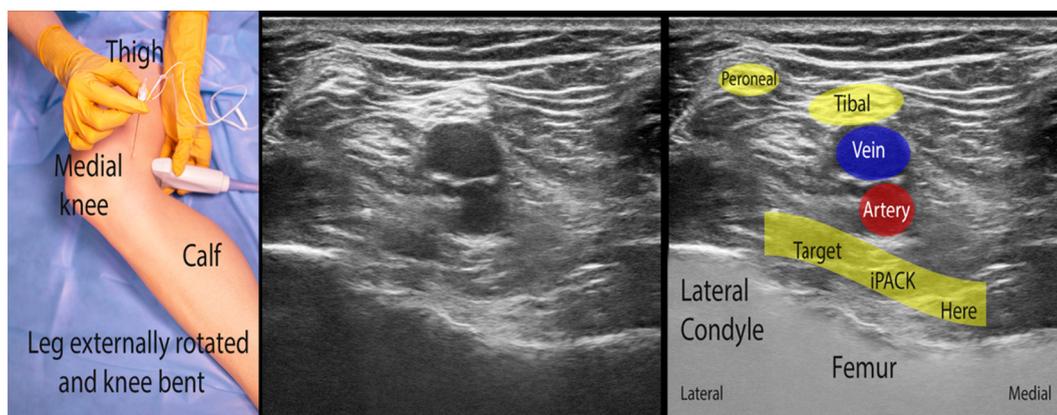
Placement of ultrasound guided infiltration of the interspace between the popliteal artery and capsule of the knee (iPACK) block. From left to right: placement of leg in preoperative holding after spinal has been placed. Operative knee is flexed and leg is externally rotated; Image from the transducer as placed in panel 1; image from the transducer with important structures labeled and target for placement of the needle.
